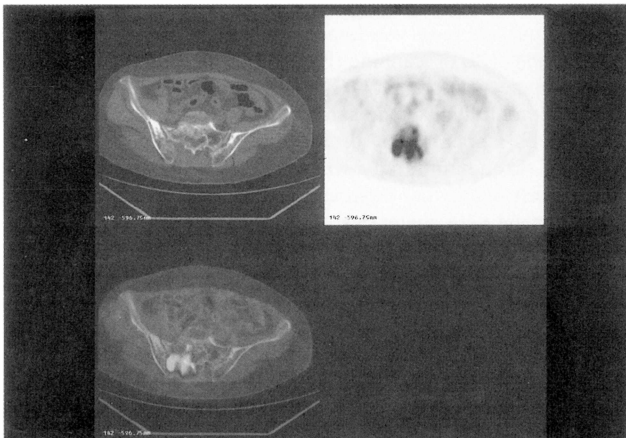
Imaging studies of case 2. A) Whole body bone scan showed heterogenous radio uptake in the right ilium and sacrum. B) Gadolinium-enhanced T1-weighted pelvic MRI demonstrated an enhanced soft-tissue mass involving the right side sacrum. C) The mass was hypermetabolic on PET.
